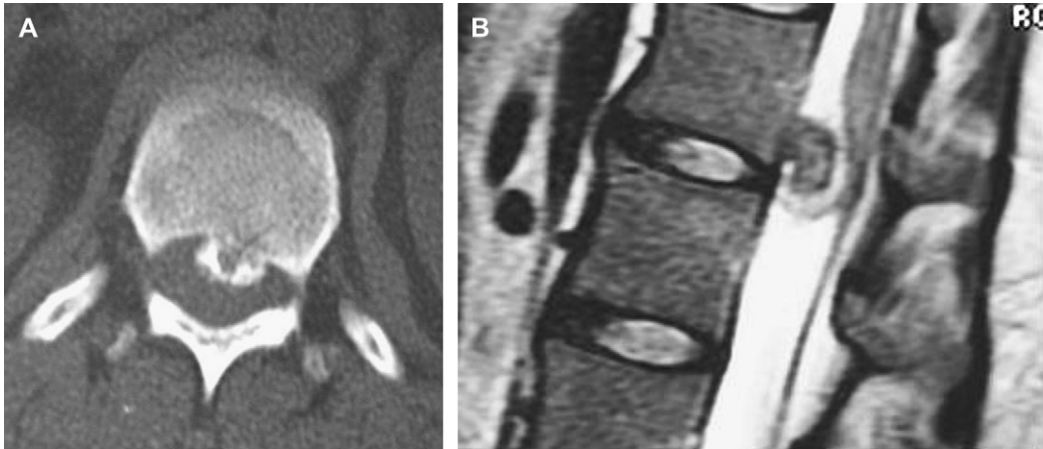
Vertebral osteochondroma shown on axial (A) CT and (B) sagittal T2-weighted MRI.
